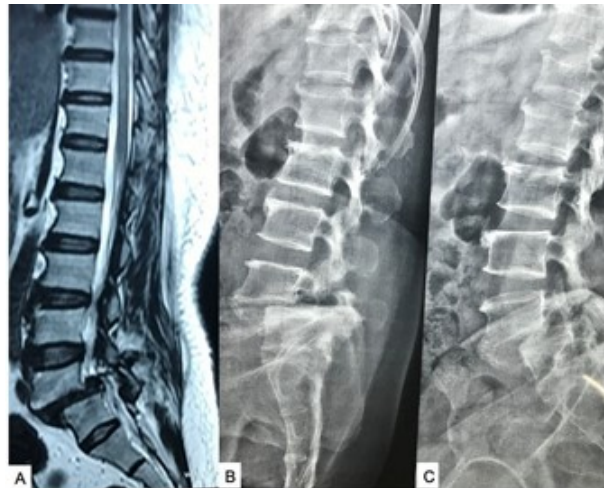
(A) MRI of lumbosacral spine (T2W sagittal image) and (B,C) dynamic X-ray of lumbosacral spine (lateral view) showing unstable grade 2 spondylolisthesis at L4 and 5 and fractured pars interarticularis with L5 sacralization. Source: Figure by authors.
